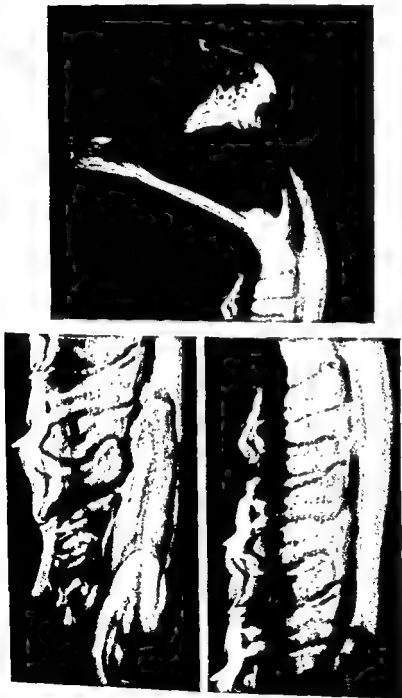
Lateral-medial radiographs of portions of right mandible of *S. cinereus*. Contact prints of higher magnification negatives of the radiograph represented in figure 14. Right: posterior portion of mandible, including third molar ($\times 20$). Upper left: region of root of incisor and cuspid, premolar and first molar ($\times 33$). Lower left: region of first to third molars ($\times 33$). Cementum obscures some details of roots of teeth and of vascular channels in bone about teeth.
